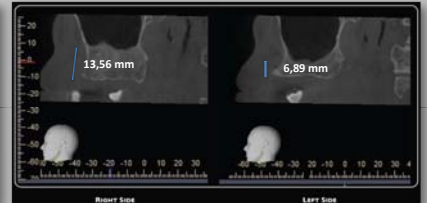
Cone Beam Computed Tomography before treatment
